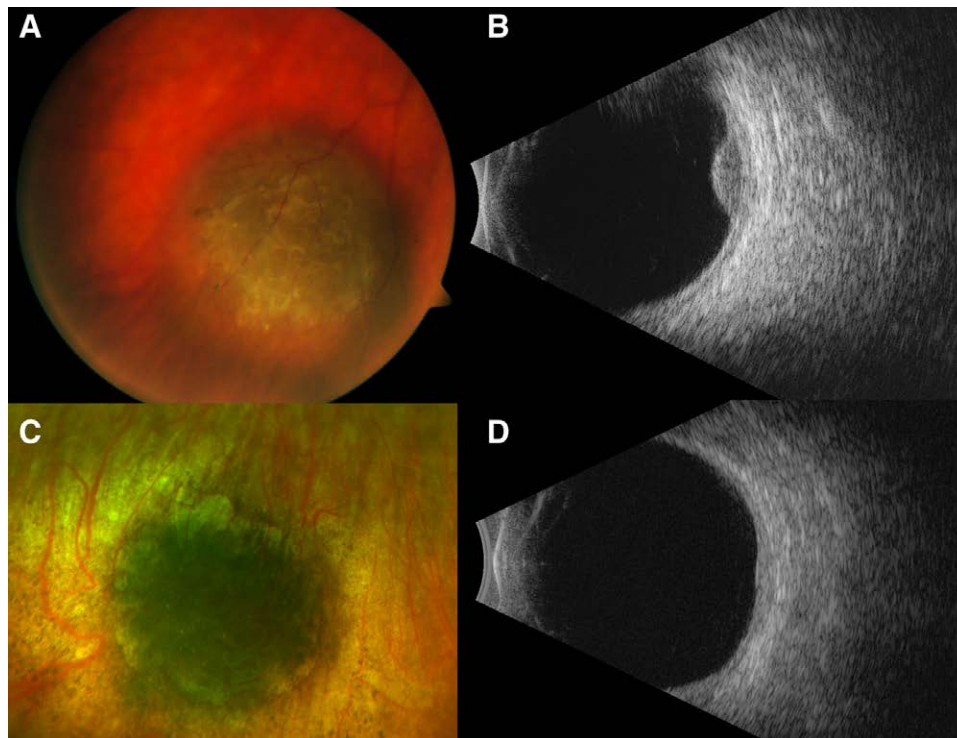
Fundus photographs and B-scan ultrasonography showing the choroidal melanoma upon presentation (A and B) and 7 years after treatment (C and D), respectively. Post-treatment, there is evidence of complete tumor regression with chorioretinal atrophy on exam (C) and flattening on ultrasound (D).
